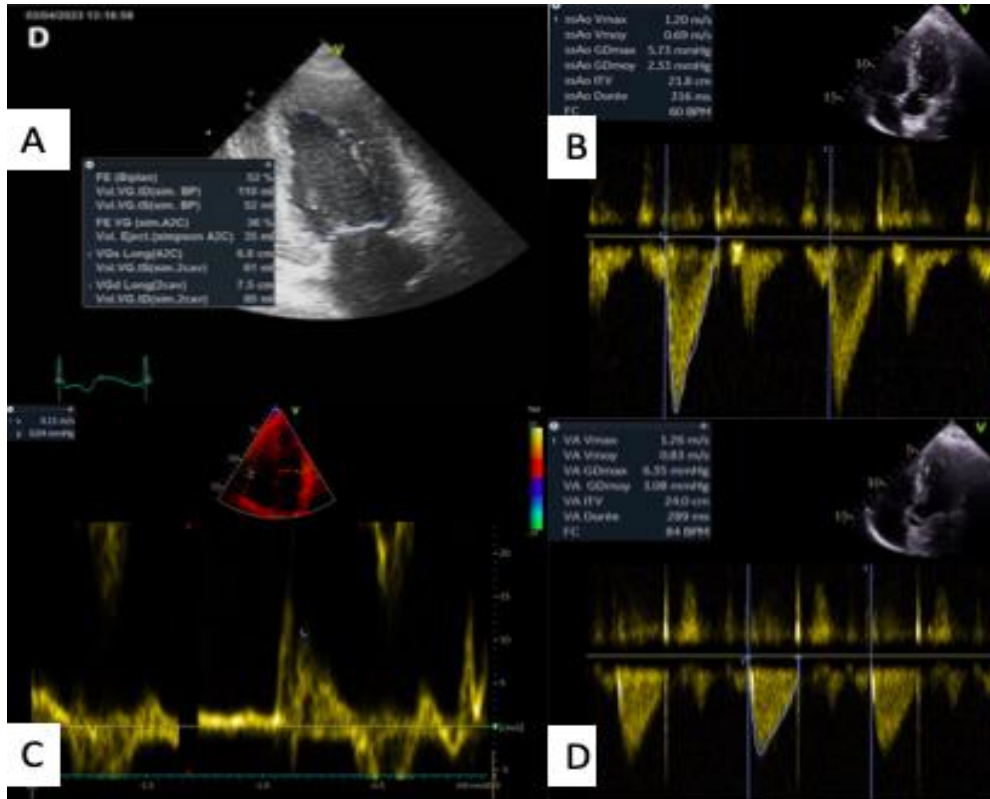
Different parameters of the echocardiography
